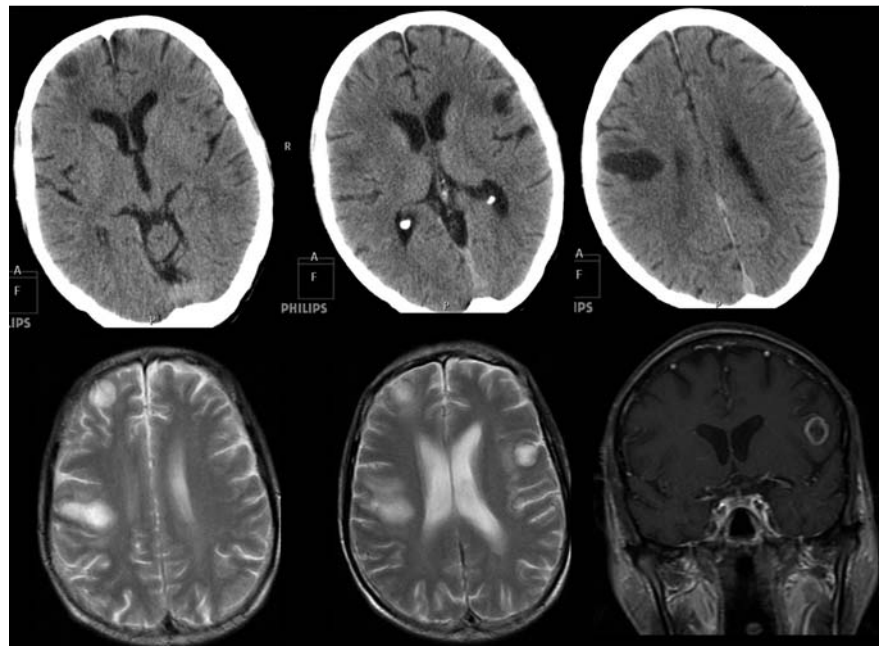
On gadolinium-enhanced T1-weighted imaging, the lesions showed intense ring enhancing. On diffusion-weighted imaging the lesion had hyperintensity, and apparent diffusion coefficient maps showed hypointensity, consistent with restricted diffusion. These changes strongly suggested the diagnosis of a brain abscess.
